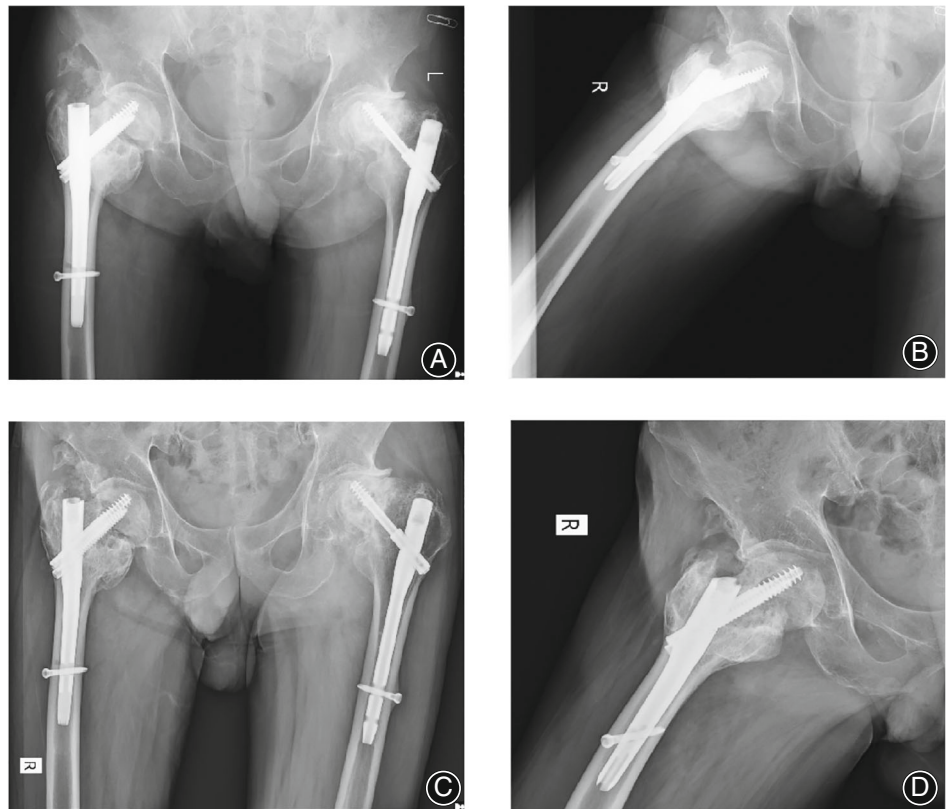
Follow-up X-rays (lateral and anteroposterior views). (A, B): 3 months after revision surgery, callus formation at the fracture end with the INTERTAN in good position 3 months later; (C, D): a healed right intertrochanteric hip fracture 1 year after revision surgery
